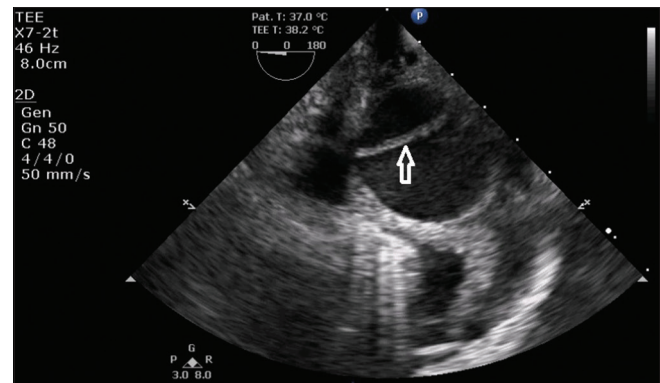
Transesophageal echocardiographic image showing dissection flap (arrow) in descending aortic SAX view
